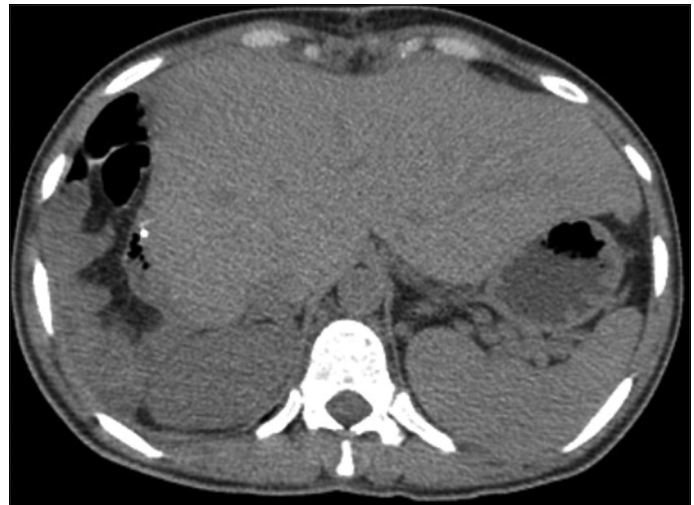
Plain computed tomography of the abdomen showing hypertrophy of the liver
